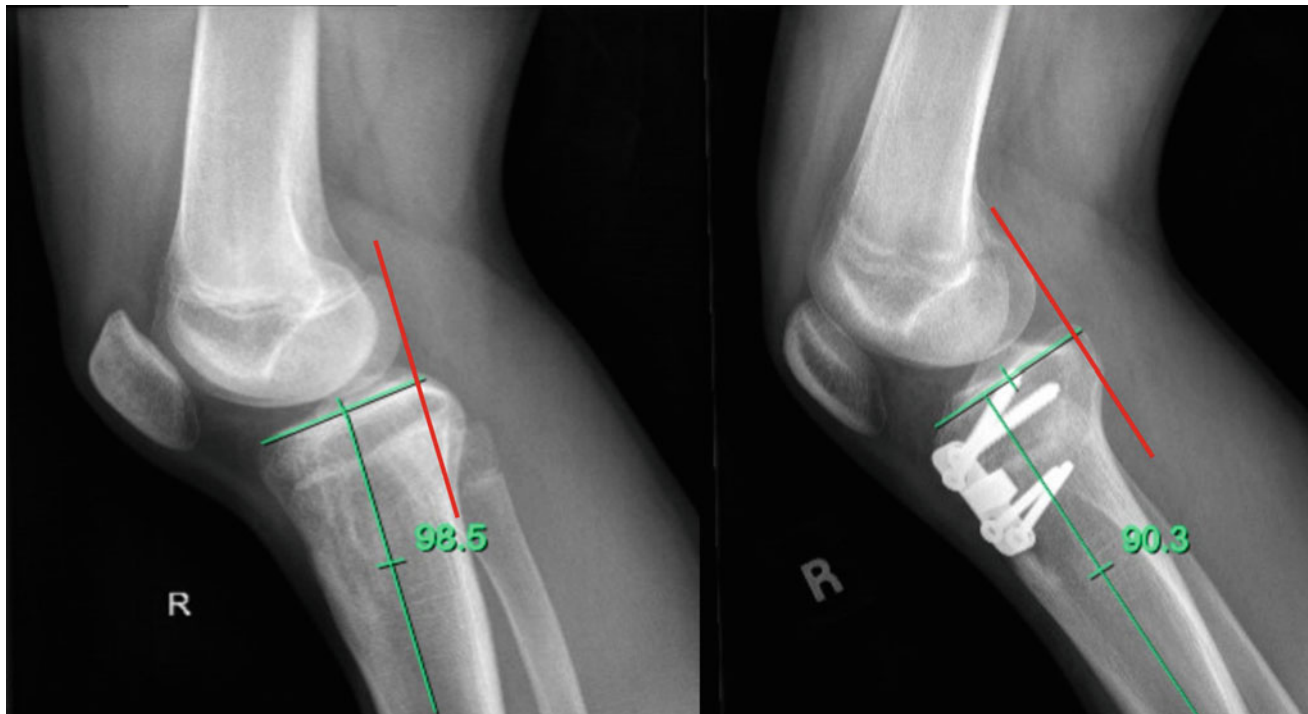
Pre- and postoperative lateral X-ray views demonstrating an anteromedial opening wedge osteotomy to increase the tibial slope in a PCL deficient knee with hyperextension deformity due to anterior
